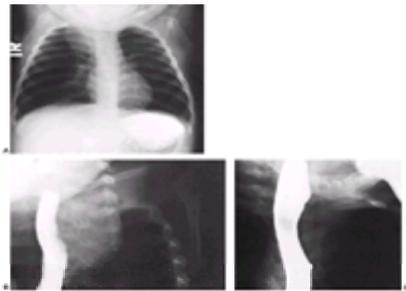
Esophageal duplication. (A) Anteroposterior chest x-ray film shows a rounded soft-tissue density of mediastinal origin. (B and C) Spot films from esophagram show pressure on the esophageal wall from an extrinsic mass. The obtuse angle of the barium above and below the mass shows it to be submucosal in origin.
